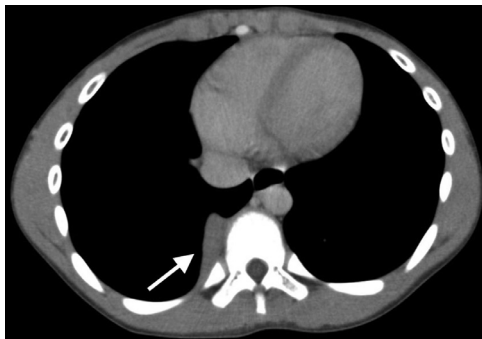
Delayed phase image of triple-phase contrast enhanced CT.
